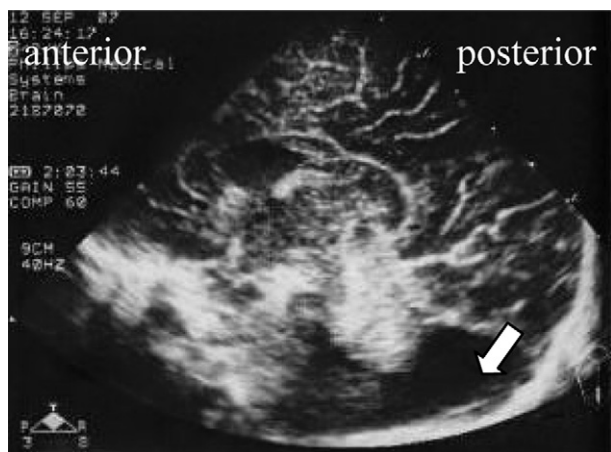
Sagittal view of brain sonography at the neonatal stage. Only a vague small cyst (arrow) at the posterior fossa was noted.
